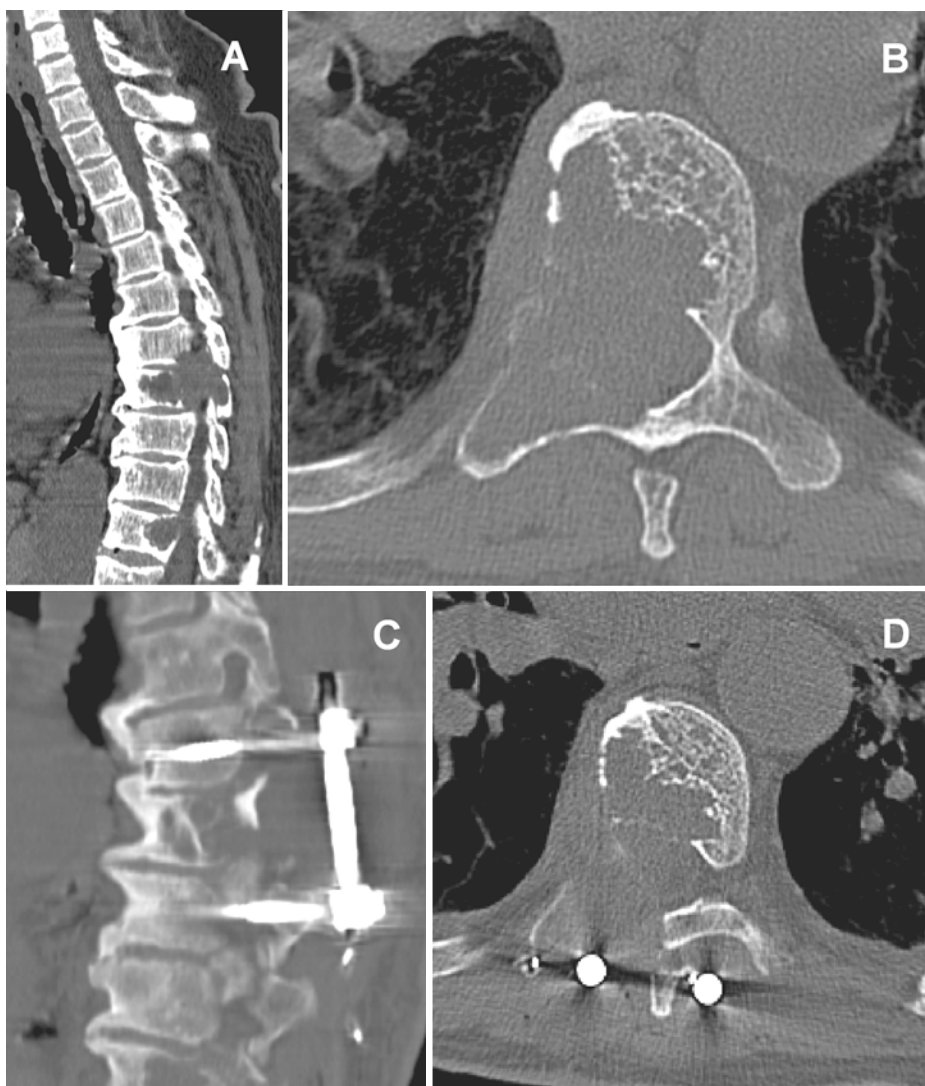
Brown tumor lesion of the lumbar spine presenting with radicular symptoms in refractory primary hyperparathyroidism. The computed tomography shows the second lumbar vertebra before (A and B) and after (C and D) curettage, hemilaminectomy and stabilization using an internal fixator.
